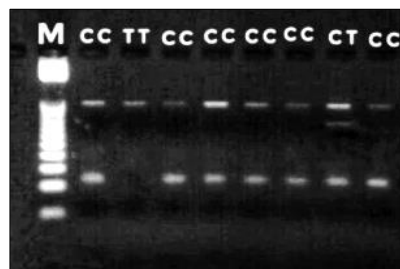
PCR RFLP results for *ABCG2* gene after digested with *MboI* restriction enzyme. The first lane (M) on the left is a ladder (25-300) bp in size, fragments have been 300bp and 62bp for wild-type homozygote CC, while RFLP-PCR product 300 bp, 150bp, and 62bp for the heterozygote CT, 300bp for Homozygote mutant variant TT.
